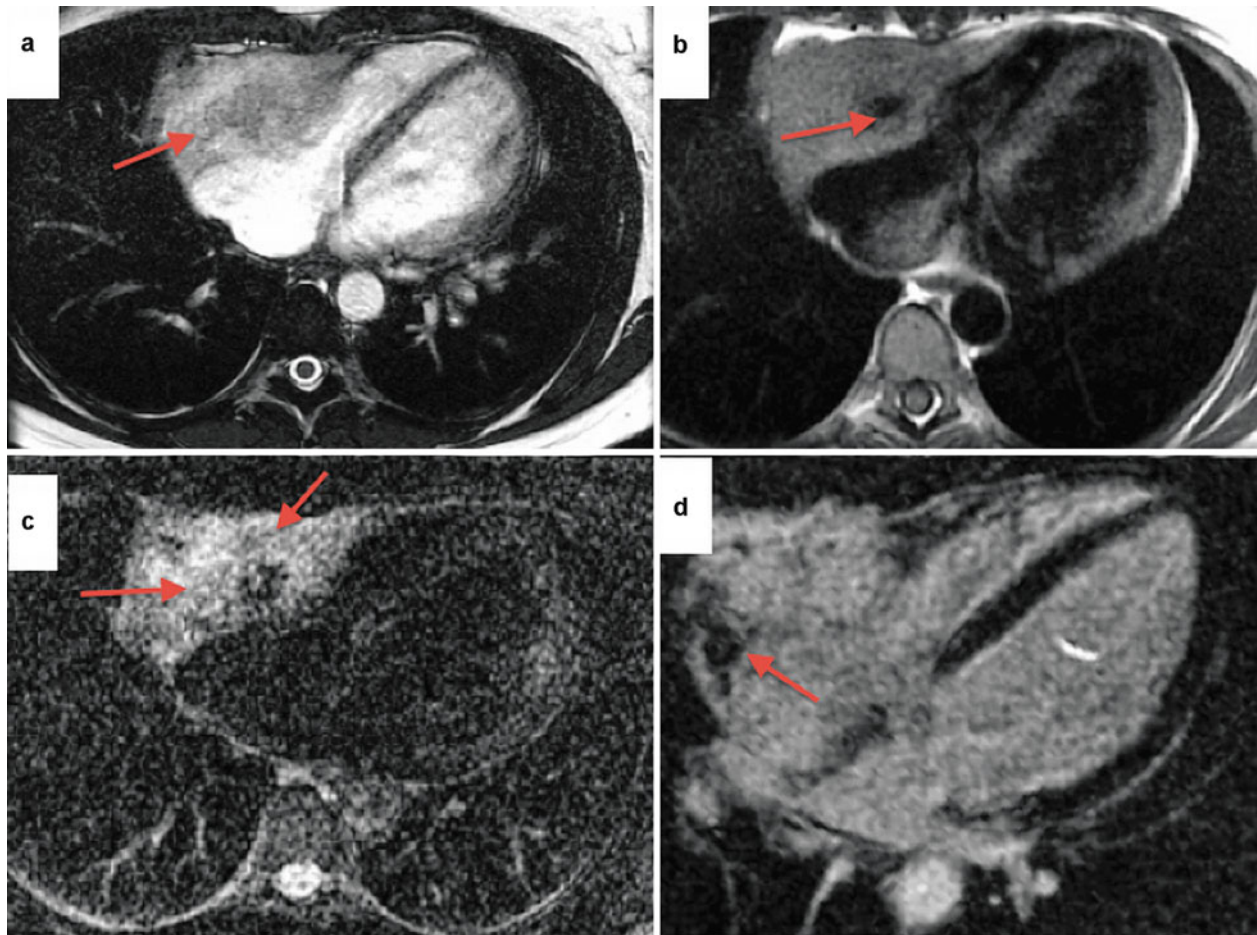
A 40-year-old female with atypical chest pain and non-sustained ventricular tachycardia underwent CMR for evaluation of a right atrioventricular groove mass. (a) Axial SSFP cine showing a large heterogeneous mass invading the right atrium and ventricle (*arrow*). (b) Axial T1-weighted DIR fast spin echo depicting a void (*arrow*) within the mass thought to be the encased and dilated right coronary artery.
